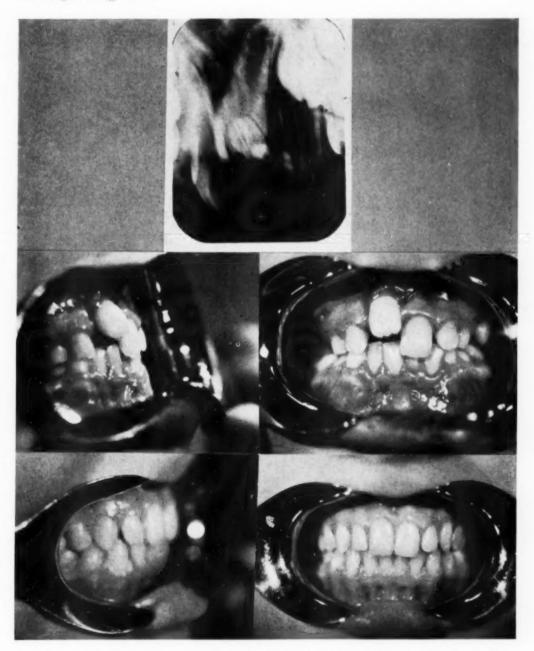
A, X-ray of a girl with six small supernumerary teeth (denticles) found while performing the extraction. B. Photograph of the same girl before, and C, after, the orthodontic treatment.
